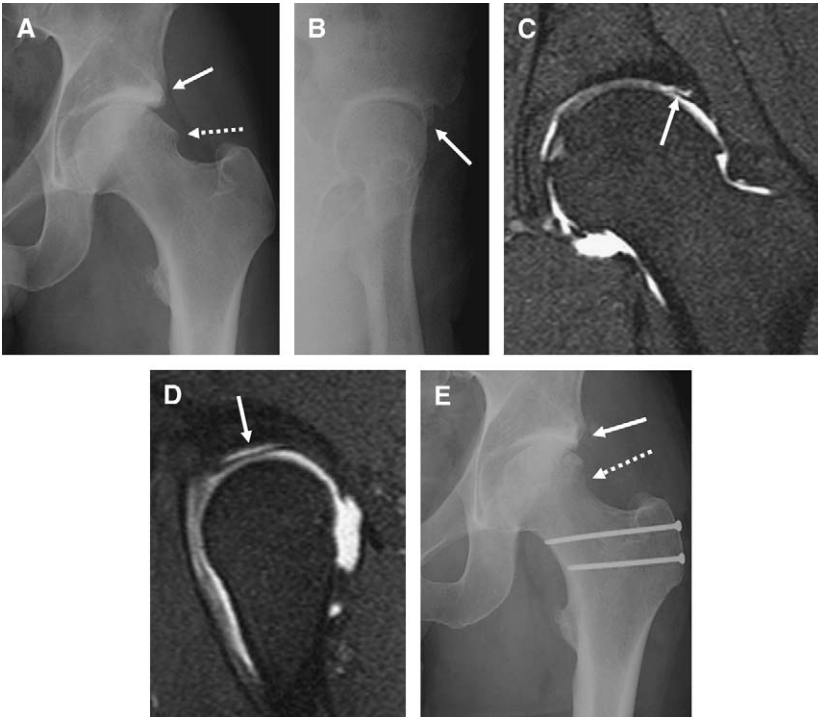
Treatment of Pincer-type FAI. The anteroposterior view (A) shows a lateral femoral bump (*dotted arrow*) as well as overcoverage of the femoral head by a hypertrophied acetabulum (*arrow*). The false profile (B) confirms the osseous hypertrophy of the anterior acetabulum (*arrow*). This represents a combination of pincer and cam type FAI. (C) The MR arthrogram shows the lateral bump and overcoverage by the acetabulum, as well as both cartilage damage and a torn labrum (*arrow*). (D) The extensive labral tear is confirmed on the sagittal plane (*arrow*). (E) The postoperative radiograph shows the treatment: the surgical approach was through the greater trochanter, which is secured by screws. The patient had a femoral neck osteoplasty (*dotted arrow*) as well as local resection of the hypertrophied acetabulum (*solid arrow*).
